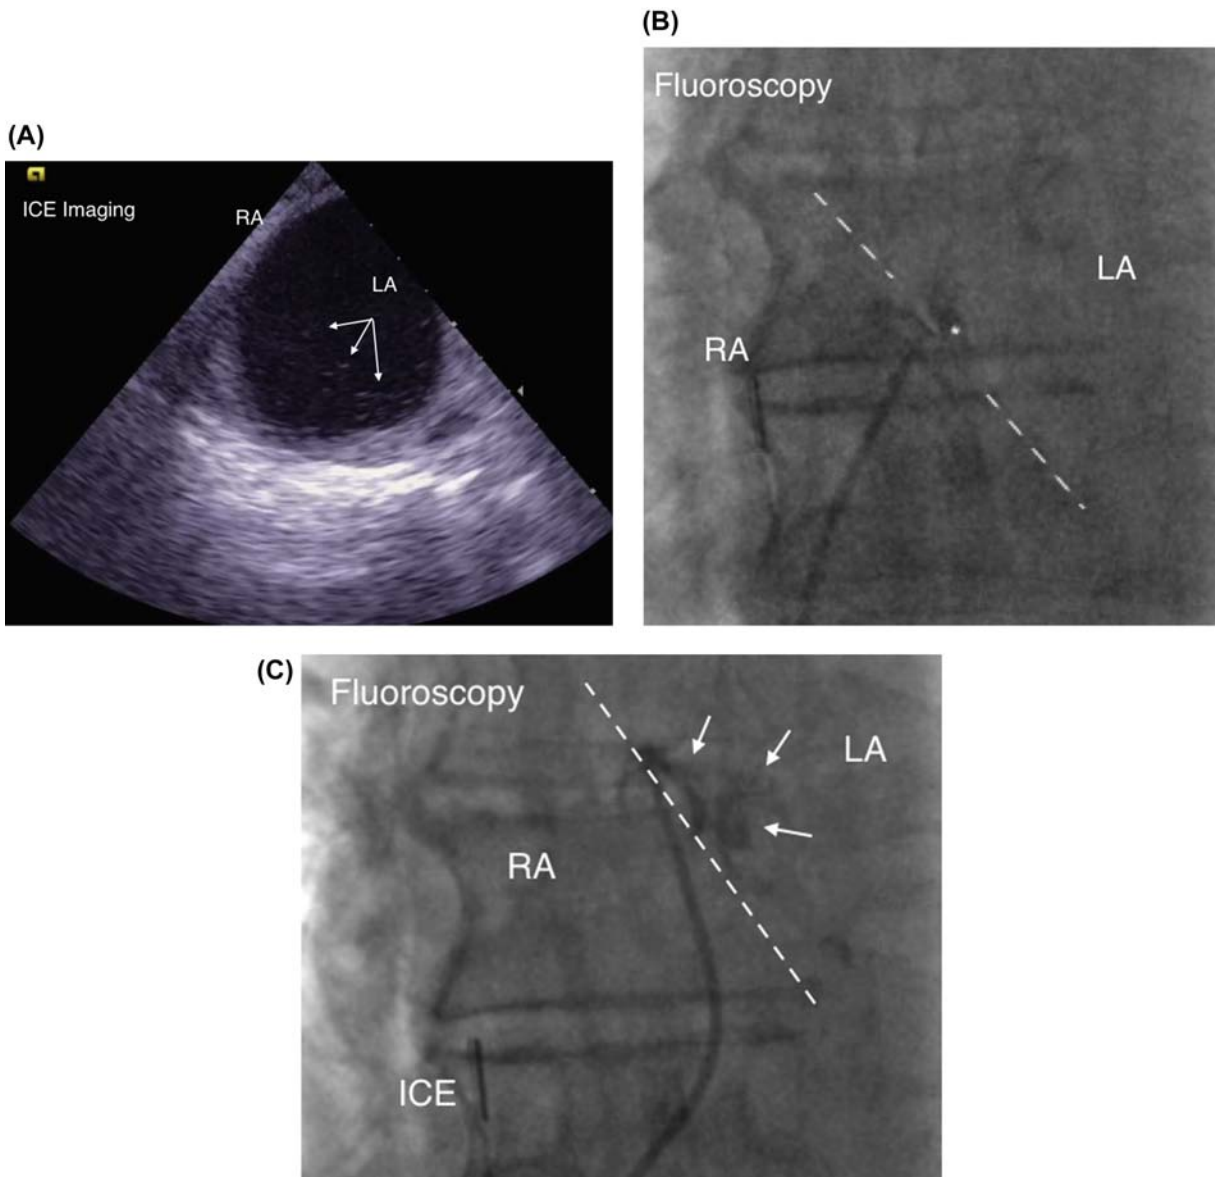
(A) An intracardiac echocardiography (ICE) image of a patient with a negative agitated saline bubble study on transesophageal echocardiography who has a positive study with ICE and a femoral injection of agitated saline. The bubbles that have crossed from the right atrium (RA) into the left atrium (LA) are marked with arrows. (B) Injection of contrast toward the septum (location highlighted by dashed white lines), revealing the origin of the PFO (indicated by the white star). (C) An injection of contrast into the PFO via the multipurpose 1 catheter which is sitting in the PFO, showing contrast spilling freely through the small PFO into the left atrium (LA). Short arrows show contrast flowing freely into the LA; dotted line shows the septum. (D) An Amplatzer Sizing Balloon inflated across the septum allowing for both fluoroscopic (left) and echocardiographic (right) measurements to choose the right PFO device. Double arrow lines show where measurements are taken at the waist. (E) From a different patient, an Amplatzer Sizing Balloon inflated through a PFO showing a large, noncompliant PFO. *ICE*, intracardiac echocardiography; *RA*, right atrium; *LA*, left atrium.
